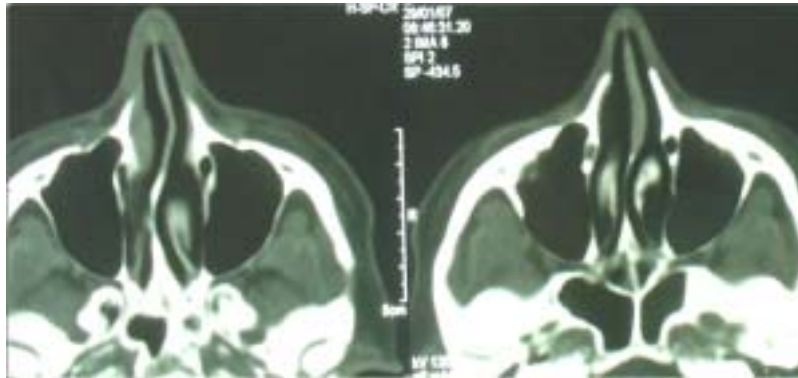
Type 4 -“S” septum – posterior curve to one side and anterior to other side (axial CT scan)
